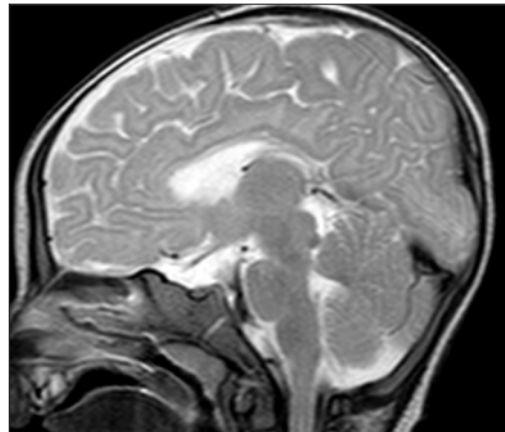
The Head MRI sagittal view showing hypoplasia of corpus callosum
